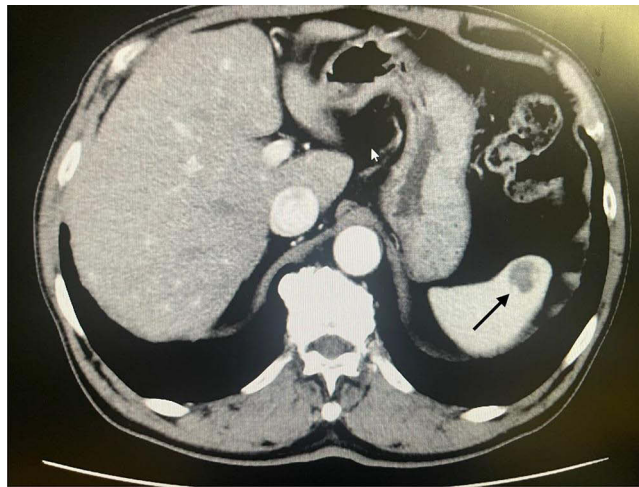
A computed tomography scan showing a splenic focal lesion (black arrow).
